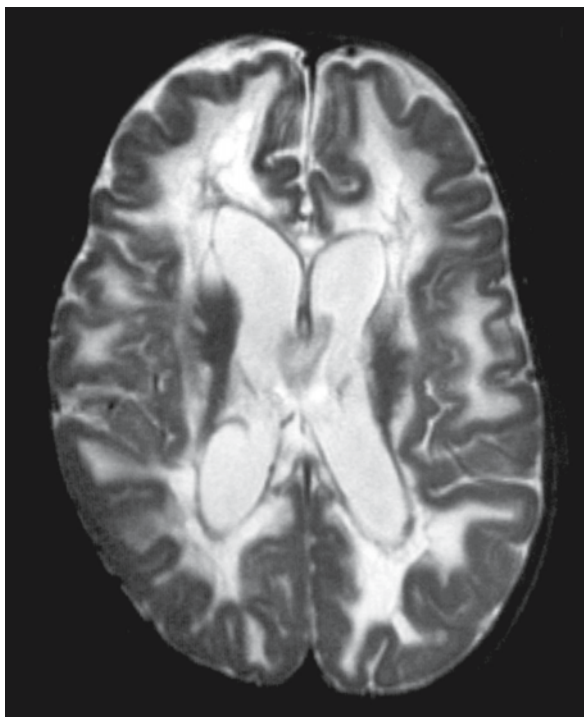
A 1-year-old girl with complex I deficiency related to a mutant NDUFV1 subunit of mitochondrial complex I (Schuelke et al. 1999). Clinically she has a severe encephalopathy and macrocephaly. The MRI reveals a diffuse leukoencephalopathy with macrocystic degeneration. Courtesy of Dr. J.A.M. Smeitink, Department of Department of Pediatrics, Nijmegen Center for Mitochondrial Disorders, University Hospital Nijmegen, Nijmegen, The Netherlands
